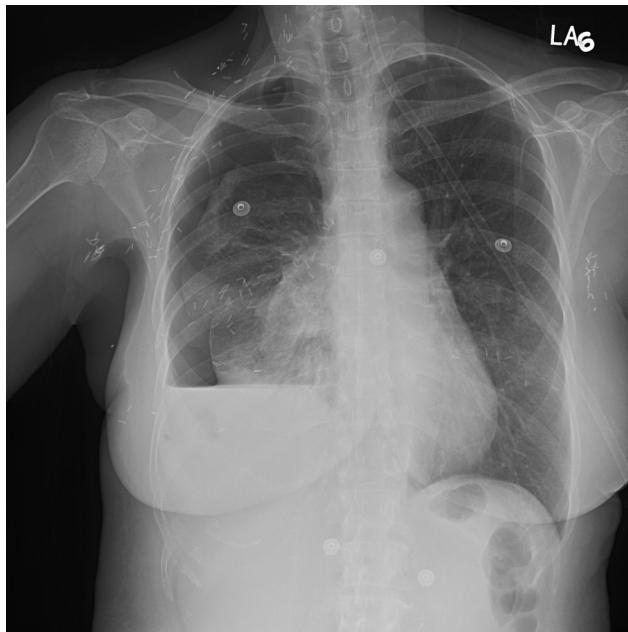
Hydropneumothorax on breast cancer patient with non-expandable lung post drainage of 1800 cc of pleural fluid. Patient had improvement of dyspnea post-procedure. There were no clinical or radiographic evidence of tension pneumothorax.
